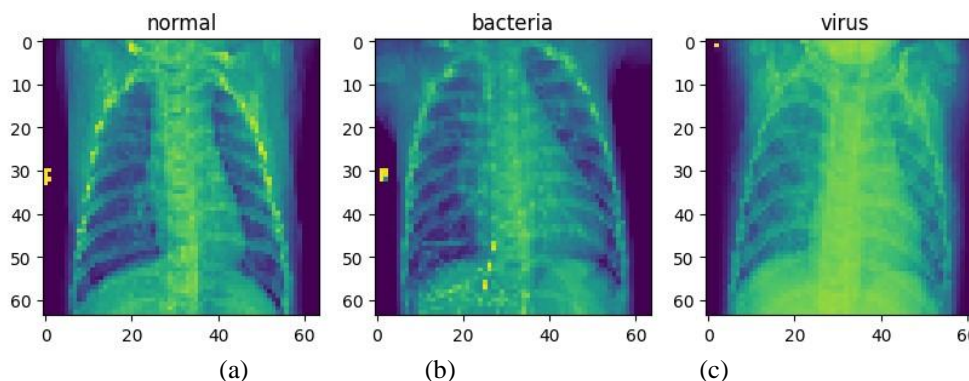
Dataset images of pneumonia variant and Normal CXR images (a) Healthy Lung (b) Bacterial Pneumonia infection (c) Viral Pneumonia Chest X-Ray images
